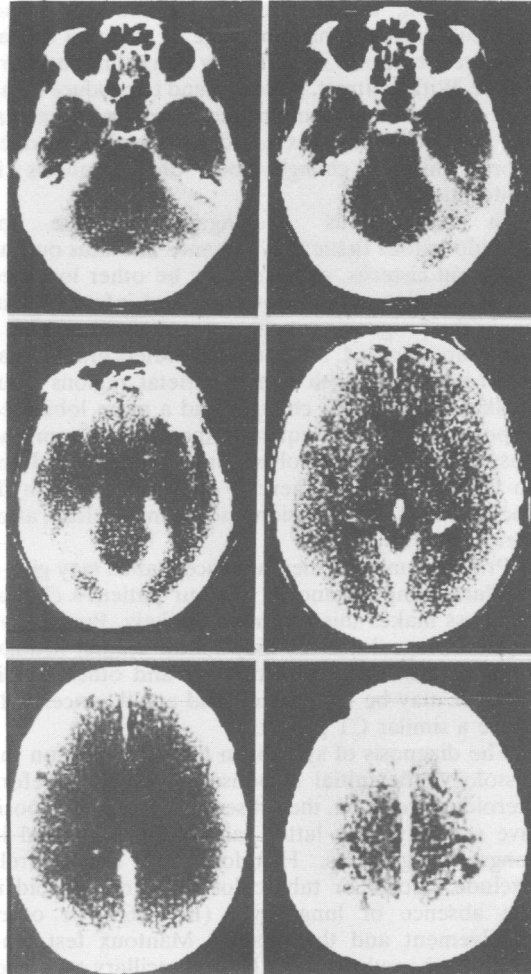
CT scan with contrast showing dural enhancement and hypertrophy particularly of the tentorium cerebelli and the falx.
